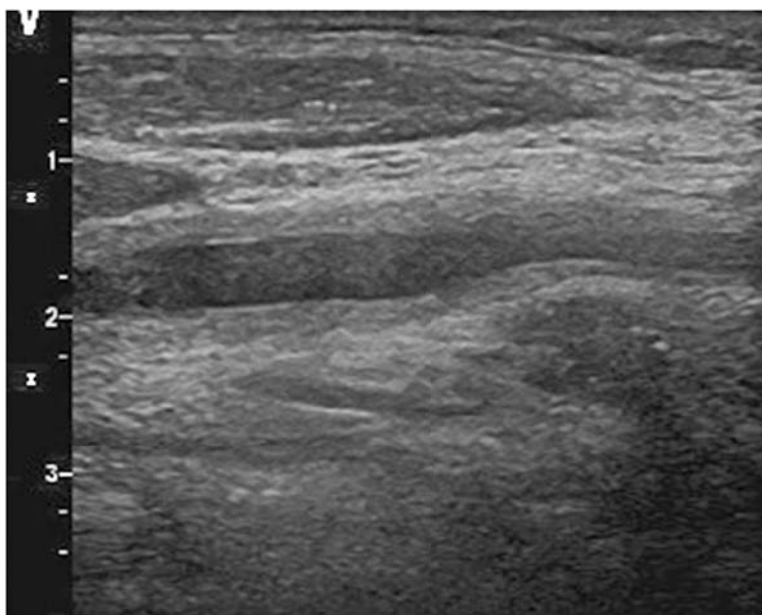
Doppler ultrasound showing narrowing of the left common carotid artery
